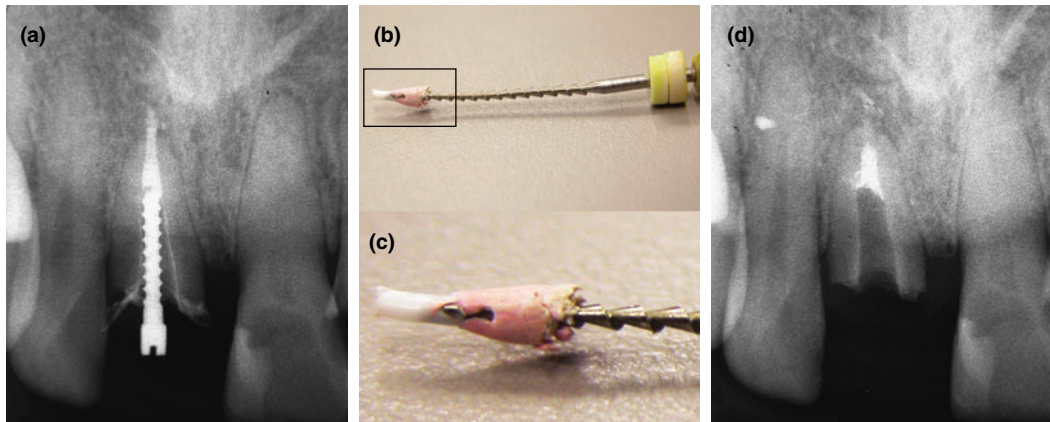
Case 3: (a) Radiograph taken after upper right central incisor underwent obturation with FP core carrier technique, showing extrusion of filling material beyond apical foramen. (b, c) FP and gutta-percha after removal with H-file. (d) Radiograph taken after root canal was refilled using adjusted FP core to fit apical stop size.
